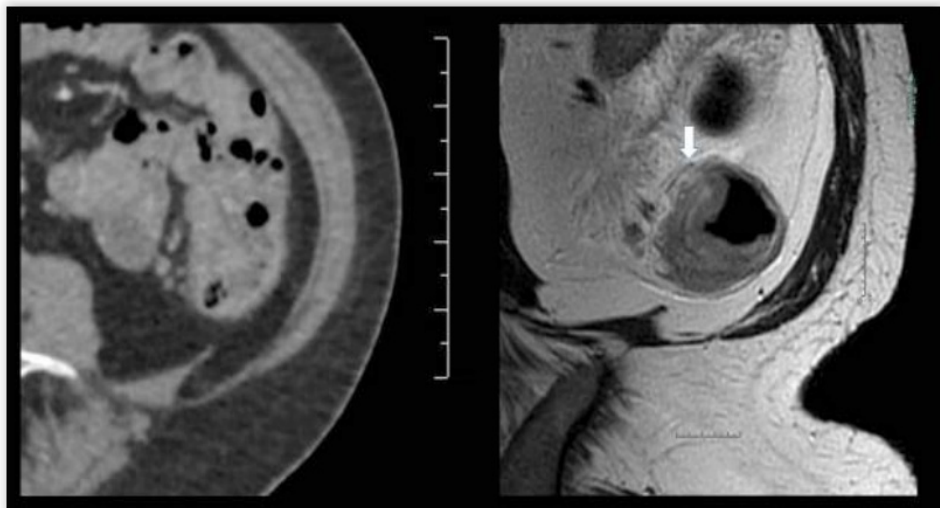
(left) The CT scan did not identify the colonic tumor, although the request indicated a tumor in the descending colon detected at colonoscopy. (right) The MRI scan showed
